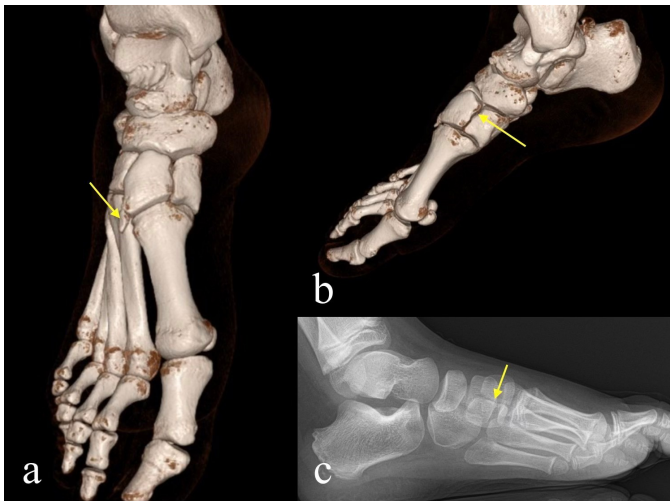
Three-dimensional tomography image of a 31-year-old man with symptomatic complete bipartition of the medial cuneiform (b) and exocytosis (a) of the 1st tarsometatarsal joint of the right foot. Lateral (c) foot radiography of thirteen-year-old male patient with symptomatic complete bipartition of the medial cuneiform.
